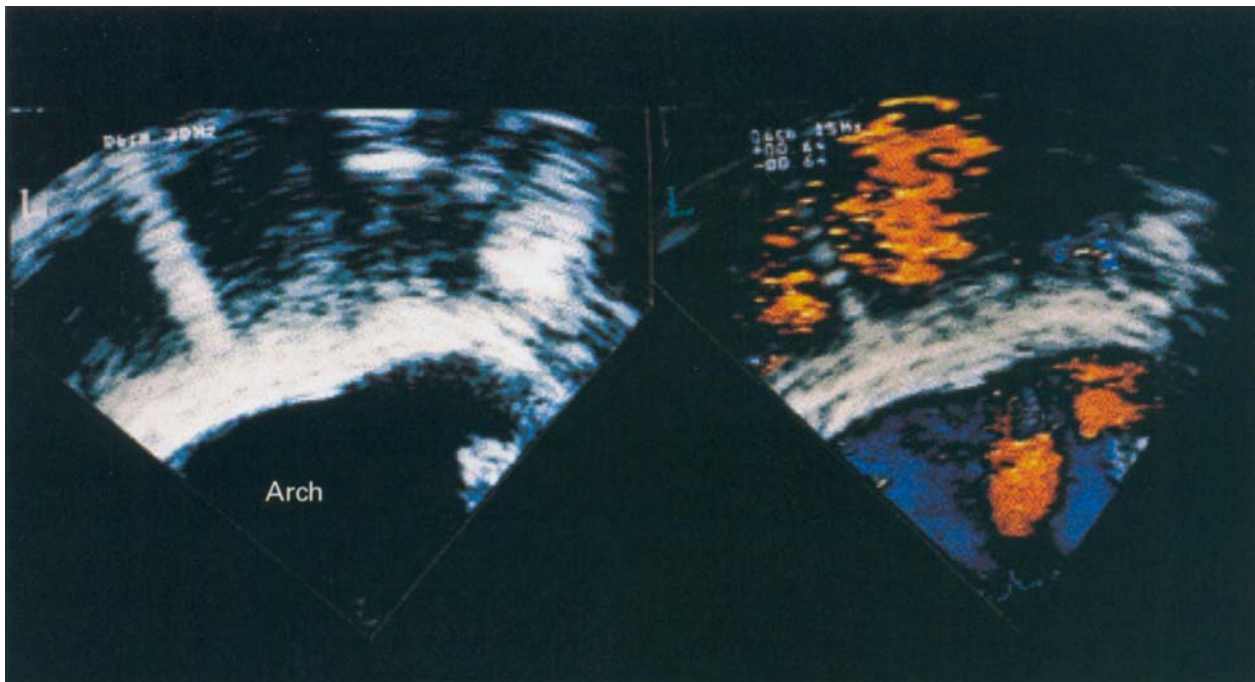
Reverberation artefact: arch of aorta. A common reverberation artefact occurs when the ultrasound beam is directed toward air-filled lung, which acts as an ultrasound reflector. Near-field structures are duplicated in the far field as a reverberation artefact. All signals are duplicated, including colour flow Doppler. This artefactual duplication of anatomy and Doppler signal should not be mistaken as a true structure. This example depicts reverberation artefact of the arch of aorta. In the far field, a reverberation artefactual aorta is imaged when the ultrasound beam is directed toward the left lung.
